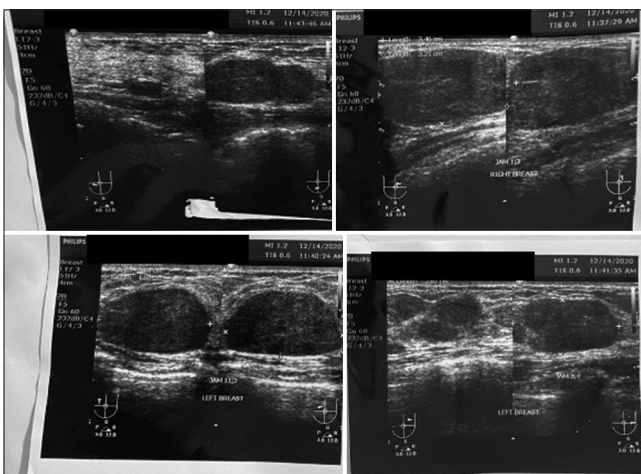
Ultrasonographic imaging of the patient's right (top) and left (bottom) breasts
